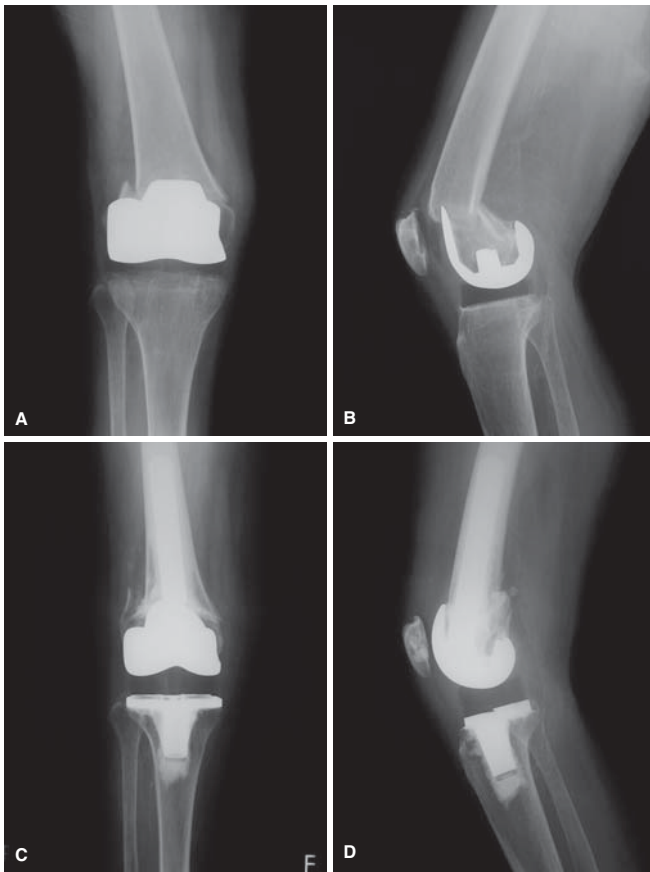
Case 1. Anteroposterior and lateral radiographs (A and B, respectively) showed a fracture above a stable right knee arthroplasty. One year after revision, anteroposterior and lateral radiographs (C and D) showed union and good alignment of components
